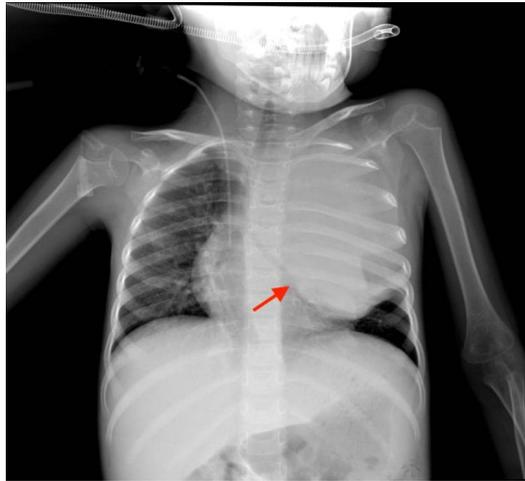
Radio-opaque mass in the upper area of the left lung in direct radiography
